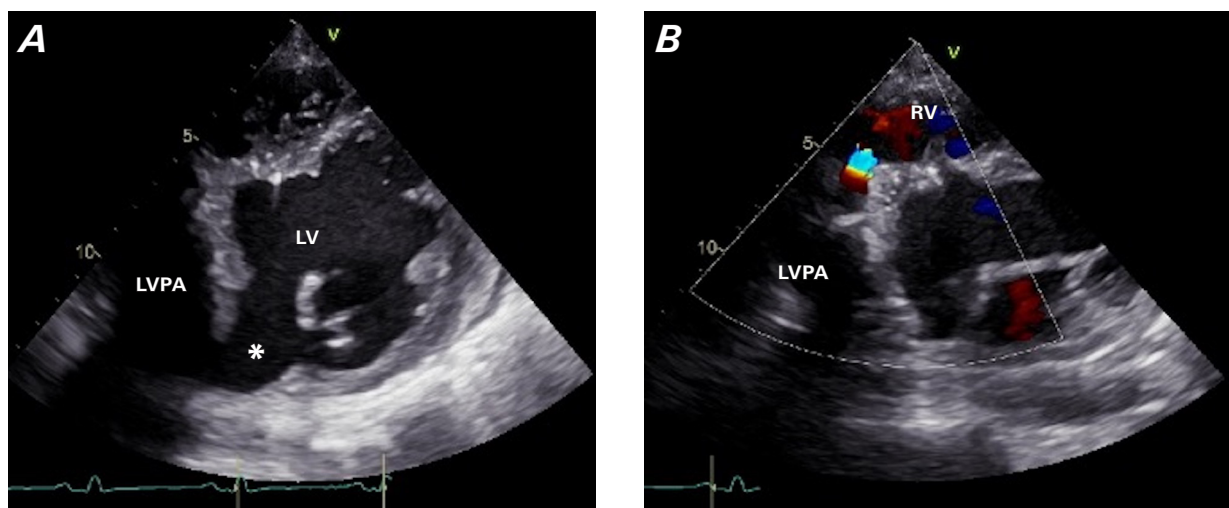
A) A transthoracic echocardiogram shows blood flow from the LV to the giant LVPA (asterisk); B) a transthoracic echocardiogram shows a shunt flow from the LVPA to the RV.
